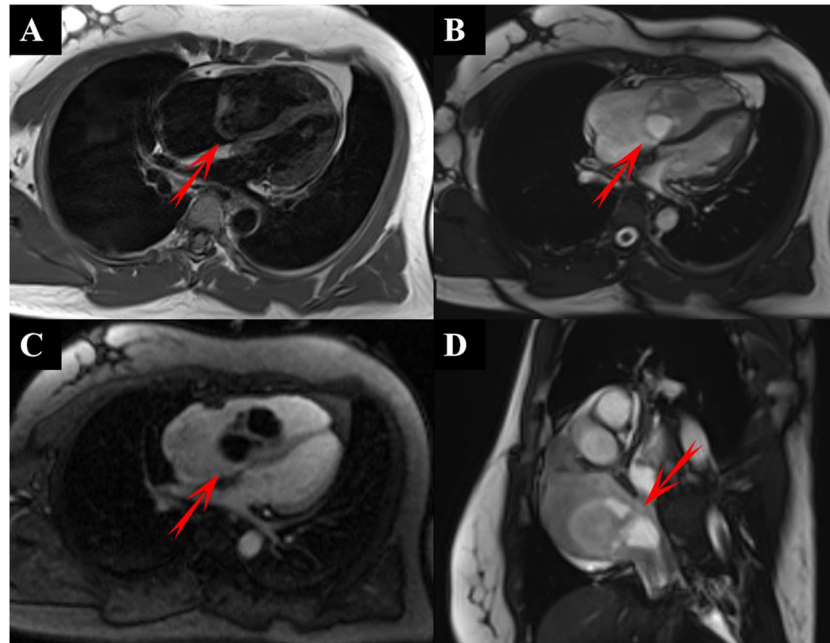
(A) T1-weighted axial magnetic resonance imaging (MRI) of the heart shows a slightly hyperintense lesion. (B) T2-weighted axial magnetic resonance imaging (MRI) of the heart shows a mixed hyperintense lesion. (C) T1-weighted enhanced scanning Axial magnetic resonance imaging (MRI) of the heart shows mild enhancement of the solids portion of the lesion. (D) T2-weighted sagittal magnetic resonance imaging (MRI) of the heart shows a lesion with a “crutch head sign.”
